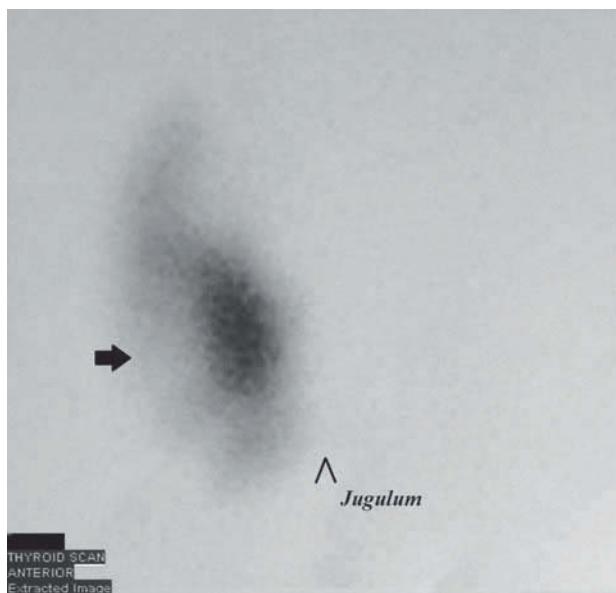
99m Tc-pertechnetate scintigraphy. Only the right thyroid lobe shows uptake (being intense and non-homogeneous) while no uptake was evident on the left side. The black arrow indicates a cold nodule corresponding to the finding of U/S.
